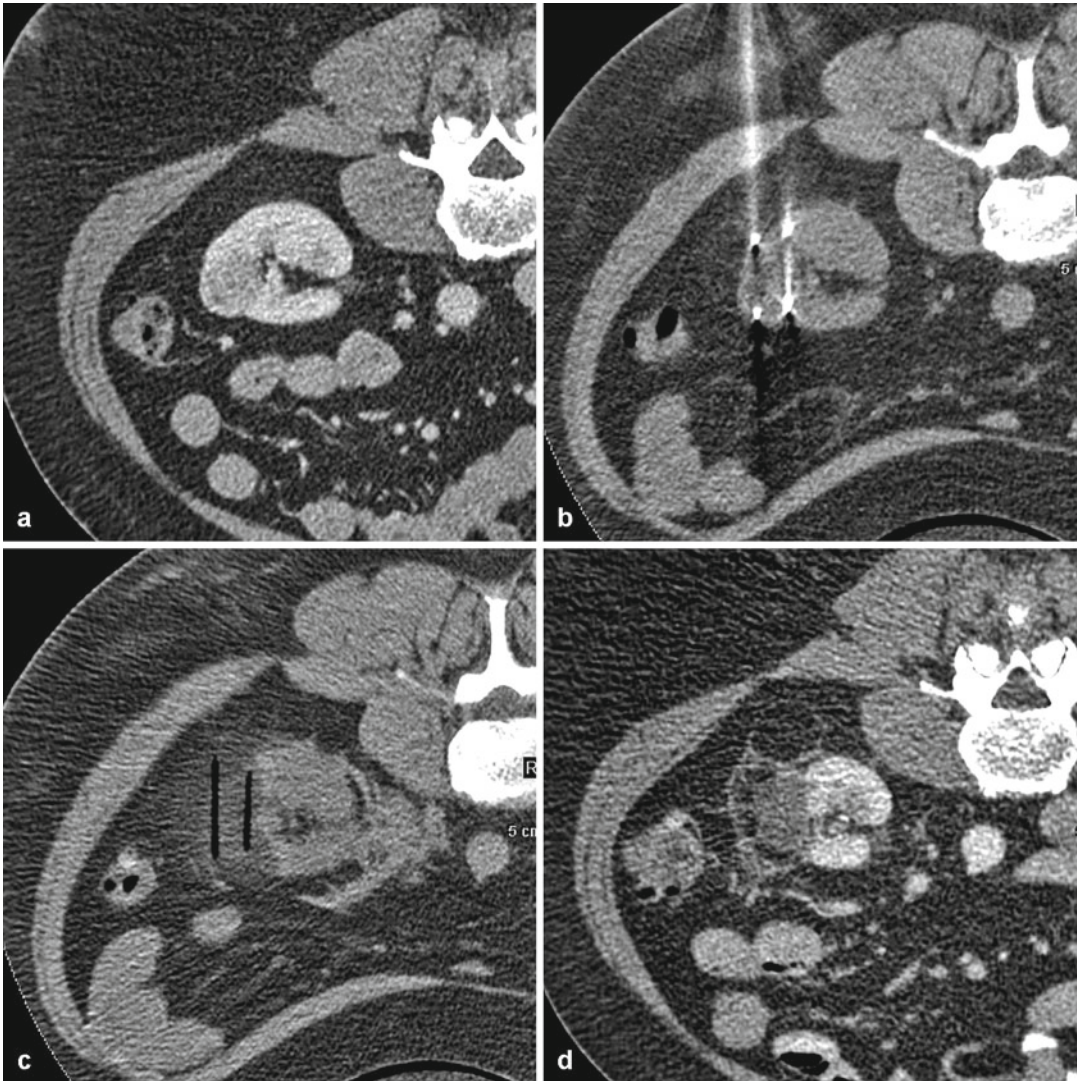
Cryoablation in a patient with renal cell carcinoma (prone position): initial CT scan shows the renal cell carcinoma in the lower third of the left kidney (a). axial CT performed during cryoablation therapy (b). Follow-up CT performed immediately after (c) and 3 months after cryoablation (d) demonstrate total devascularized of the tumor without tumor recurrence
